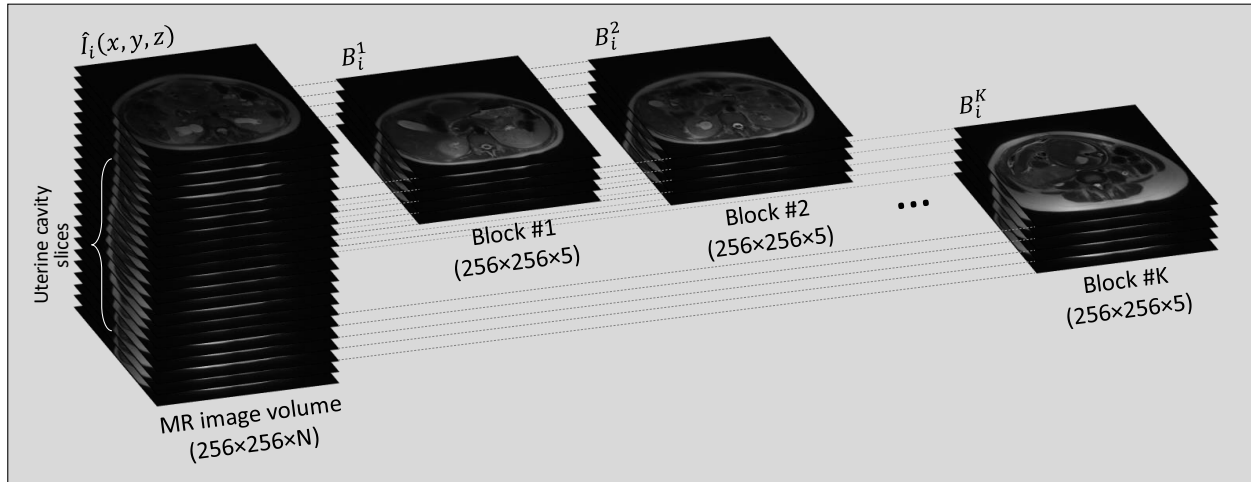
Image blocks extraction from a 3D MR image volume.
